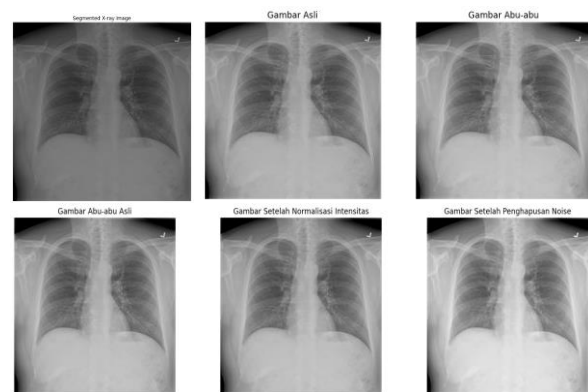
X-Ray Lung Images
